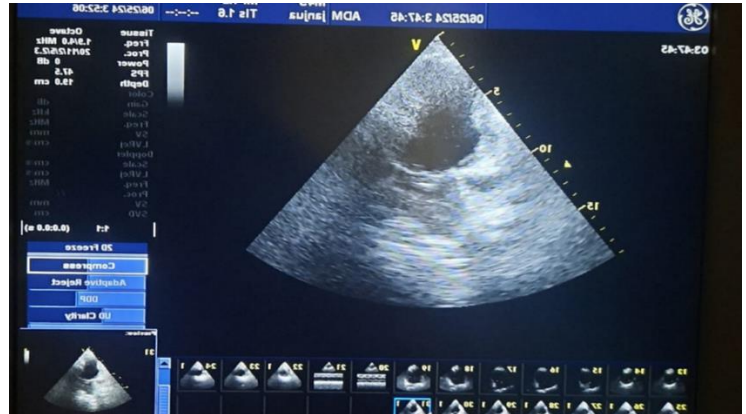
The follow-up echocardiography after one month of treatment; Parasternal short axis view showing improvement in left ventricular ejection fraction.
